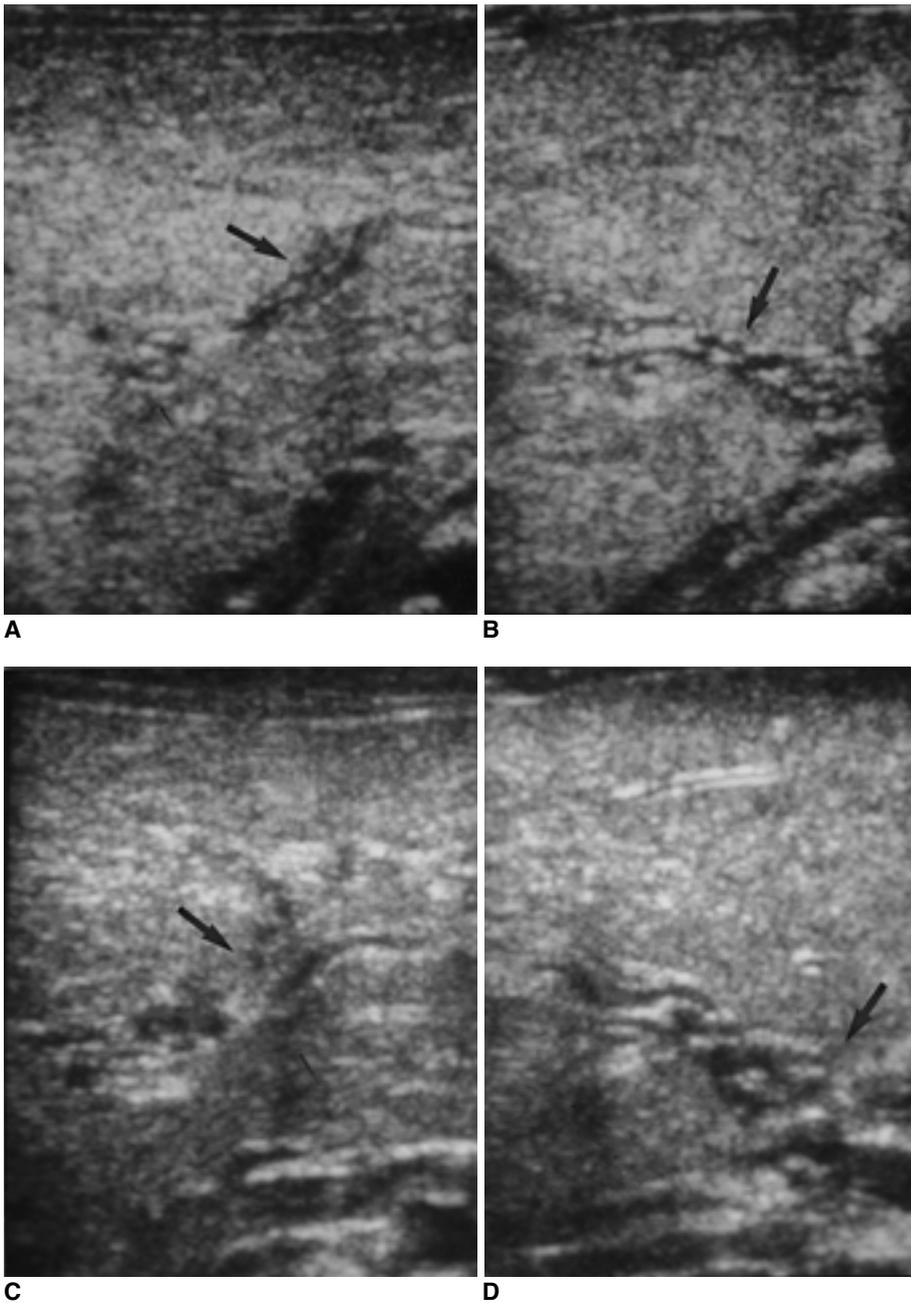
Obstructive thromboses within the entire portal veins in an 1-month-old infant in group III. Transverse US images show completely obstructed left portal vein(A) and main portal vein(B) with echogenic thromboses. Serial follow-up sonogram after 22 days depicts completely thrombosed left portal vein(C) and main portal vein(D). Multiple serpiginous vascular channels around the thrombosed portal veins are formed.
